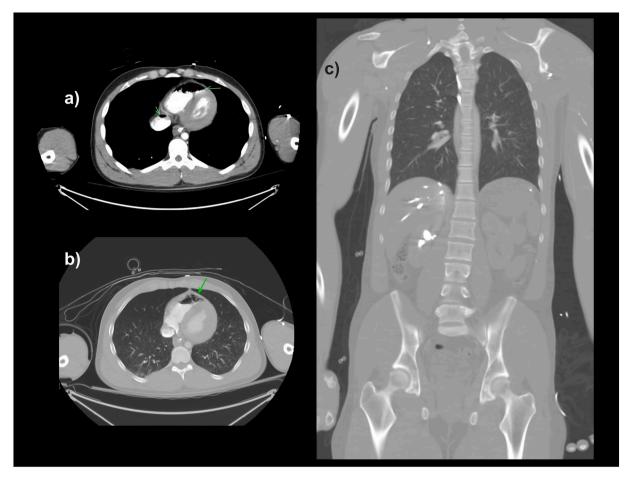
Chest CT with contrast showing (a) air embolism in the right ventricle and pulmonary vein, and (b) axial and (b) sagittal view showing unaffected lung tissue.
